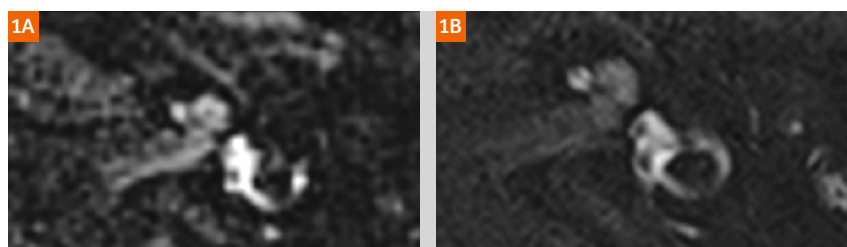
3D SPACE FLAIR (1A) and 3D real IR (1B) imaging of a normal left inner ear. There are no indications of enlarged endolymphatic spaces and displacement of Reissner's membrane.
